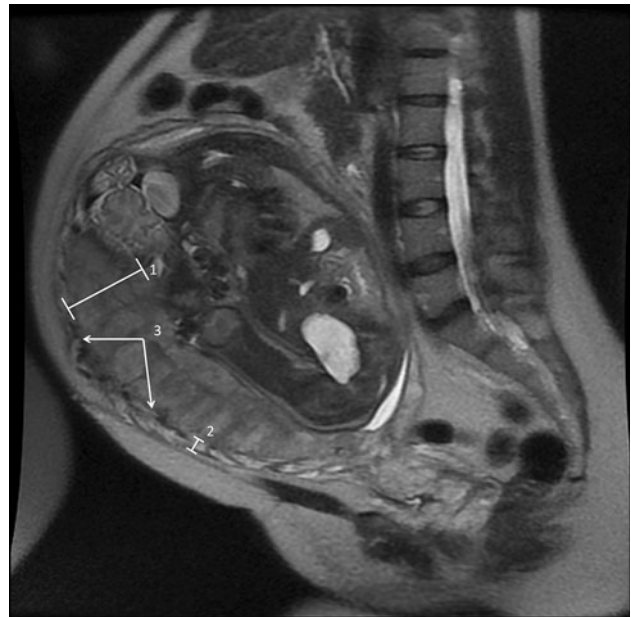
The abdominal magnetic resonance image of the patient showing (1) placenta, (2) myometrial lining, and (3) myometrial thinning, placental bulging, and thickened linear septations that raised the suspicion of placenta accreta
